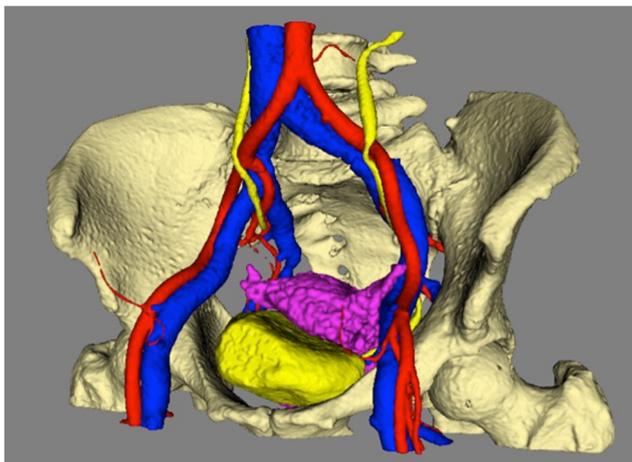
Example of the final result of the CE-CT image segmentation process: the patient's 3D model of the pelvis can be zoomed, rotated and seen from different perspectives
